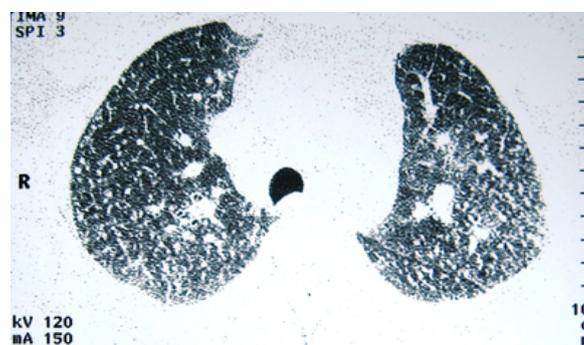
Number 1 technician's pneumoconiosis diagnosed HRCT.
